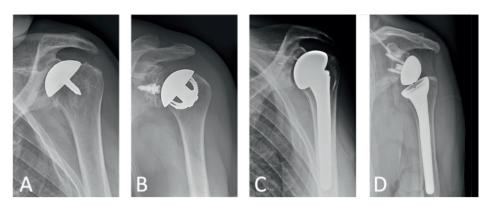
Anteroposterior radiographs of left shoulders
